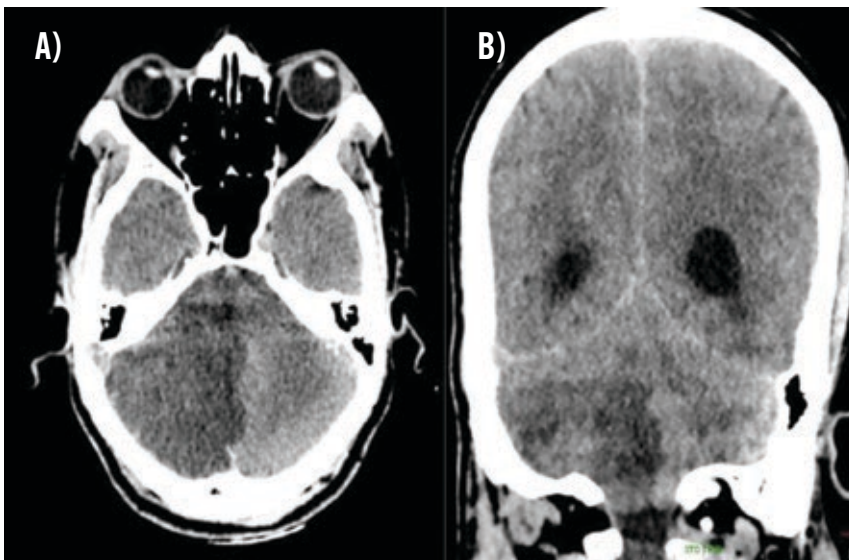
A) CT brain axial and B) CT brain coronal showing a right posterior cranial fossa lesion that is hypodense
